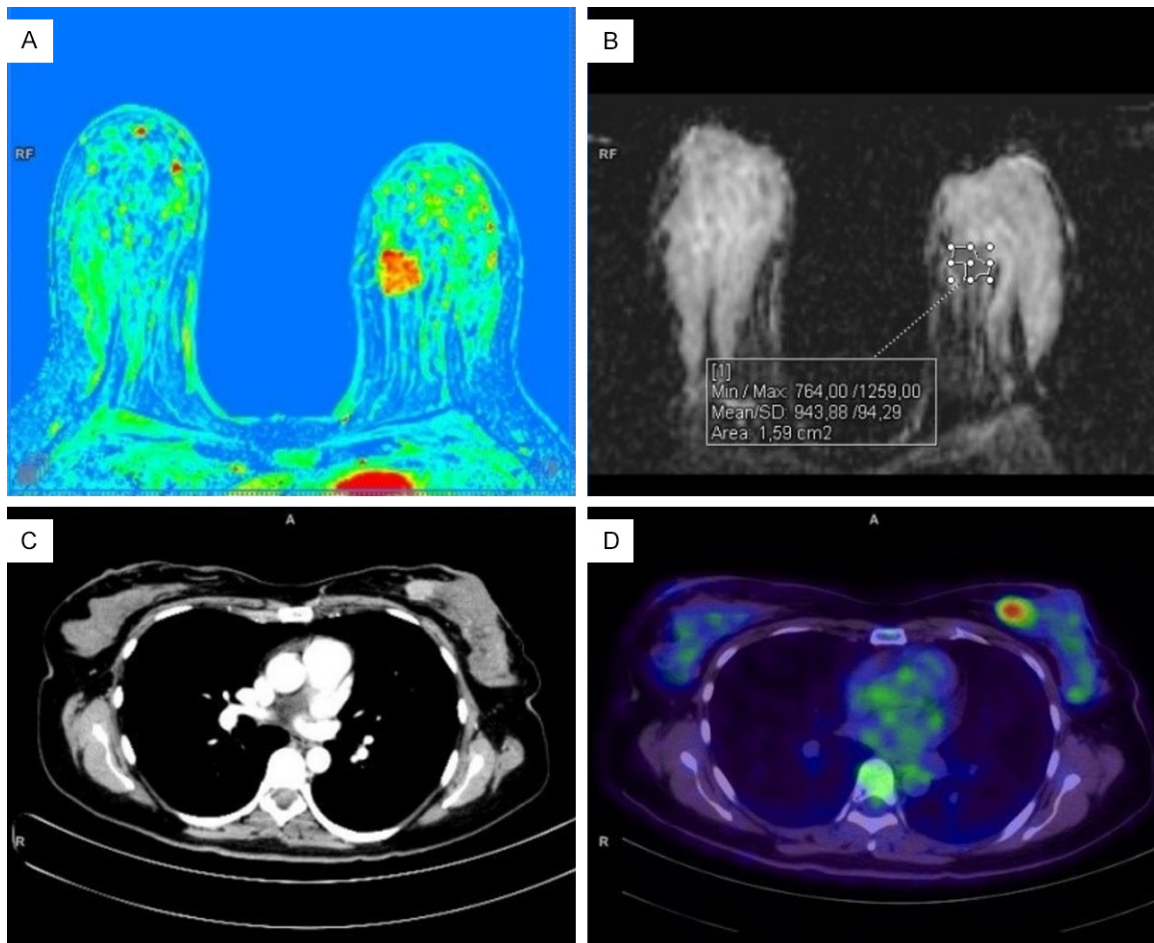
Breast MRI (upper row) and whole-body PET/CT with ^{18}F -FDG (lower row) in a patient with invasive breast cancer. A. The perfusion map shows a hypervascular tumor in the inner quadrants of the left breast. B. ADC map with an example of freehand ROI placement. C. CT scan with intravenous contrast (iopamidol) - a component of combined PET/CT. D. A significant increase in tumor metabolism was detected via PET/CT with ^{18}F -FDG.
